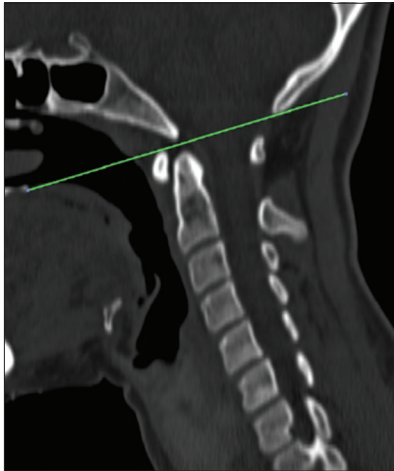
Sagittal section of computed tomography scan showing the McGregor line
